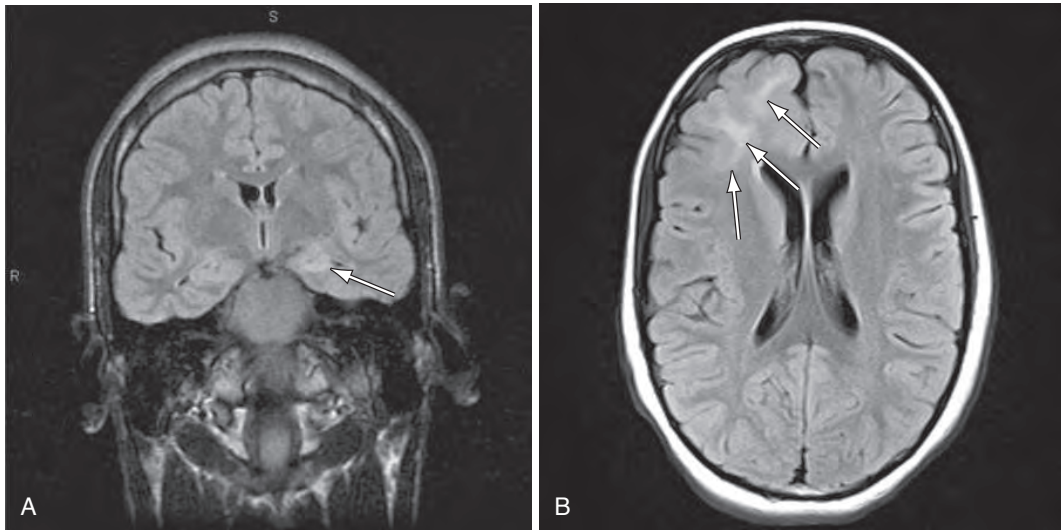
A, Coronal fluid-attenuated inversion-recovery (FLAIR) MRI scan of a 13 yr old with intractable seizures and mesial temporal sclerosis (MTS). The arrow points at the hippocampus with the high-intensity signal characteristic of MTS. B, Axial FLAIR MRI of a 7 yr old with intractable seizures and right frontal cortical dysplasia. The arrows point at the high-intensity signal corresponding to the dysplasia. (A from Lee JYK, Adelson PD: *Neurosurgical management of pediatric epilepsy*, *Pediatr Clin North Am* 51:441–456, 2004.)
